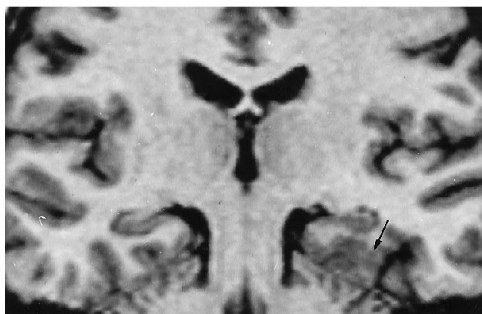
Patient 2: focal cortical malformation of the temporal cortex. Oblique coronal T1-weighted section at the level of the body of the hippocampal formation. The cortical ribbon of the left occipitotemporal gyrus was thickened (arrow). No area of increased signal was visible on T2-weighted images (not shown). The hippocampal formation had a normal morphology.
